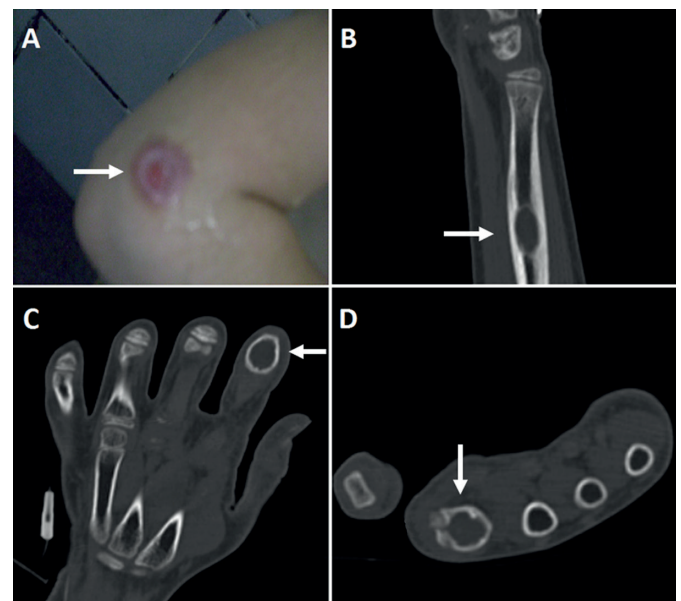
(A): erythematous pustular lesion on the lateral aspect of the elbow. (B-D): computed tomography showing multiple well-delimited osteolytic lesions without a sclerotic halo (arrows) affecting the left ulna, metacarpals, and phalanges (B-D), with no evidence of periosteal reaction.
